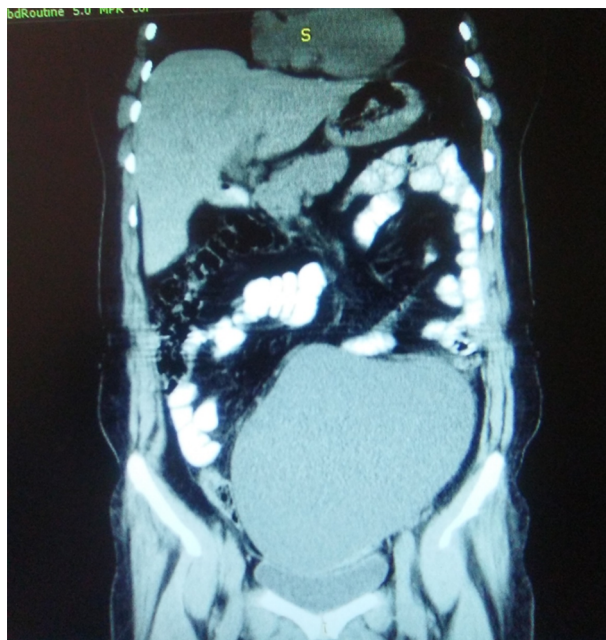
CT Scan of the Retroperitoneal Cystic Mass Up to the Top of the Bladder
